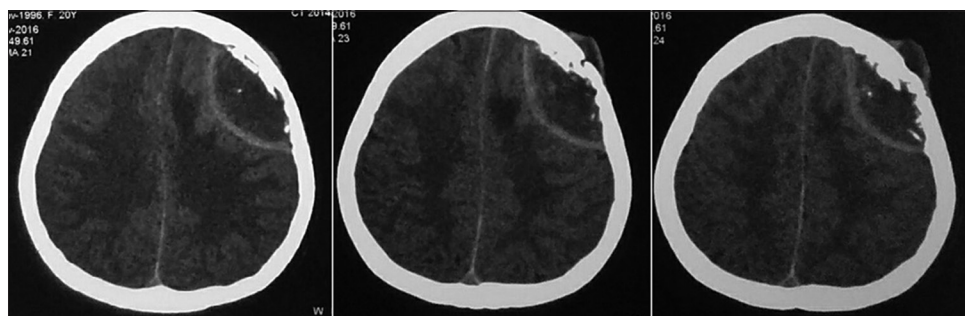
Plain axial computed tomography showing lentiform shaped collection in the extradural space of left frontal region. The destruction of bone along with scalp involvement is also noted
